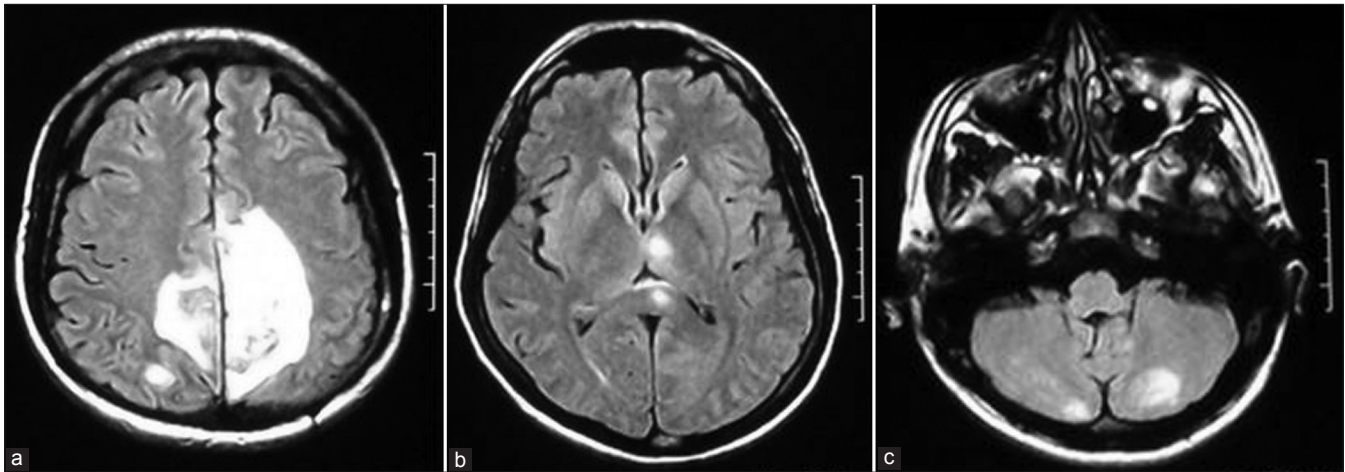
(a) Magnetic resonance imaging (MRI) (Flair) showing bilateral parasagittal parietal hemorrhagic infarcts. (b) MRI of the brain (Flair) showing infarcts in the splenium of corpus callosum and left thalamus. (c) MRI (Flair) showing infarcts in both the cerebellar hemispheres
